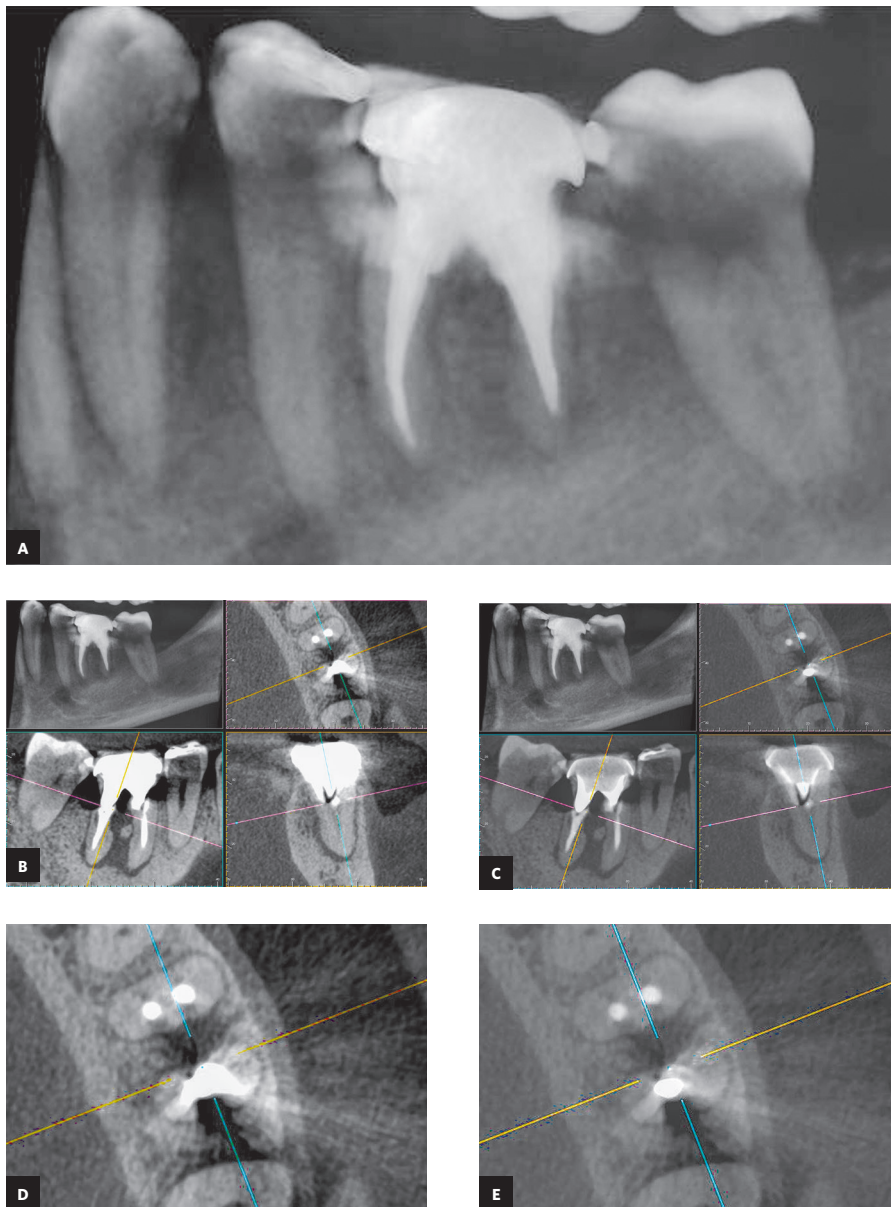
The original CBCT scans (A) revealed that tooth #46 had a treated root canal and a metal restoration extending to the coronal aspect of the canal. A white contrast artifact made it impossible to determine the occurrence of root perforation associated with the intraradicular post (B, D); the BAR filter was used to reduce the metal artifacts making it possible to confirm root perforation at the furcation level (C, E).
